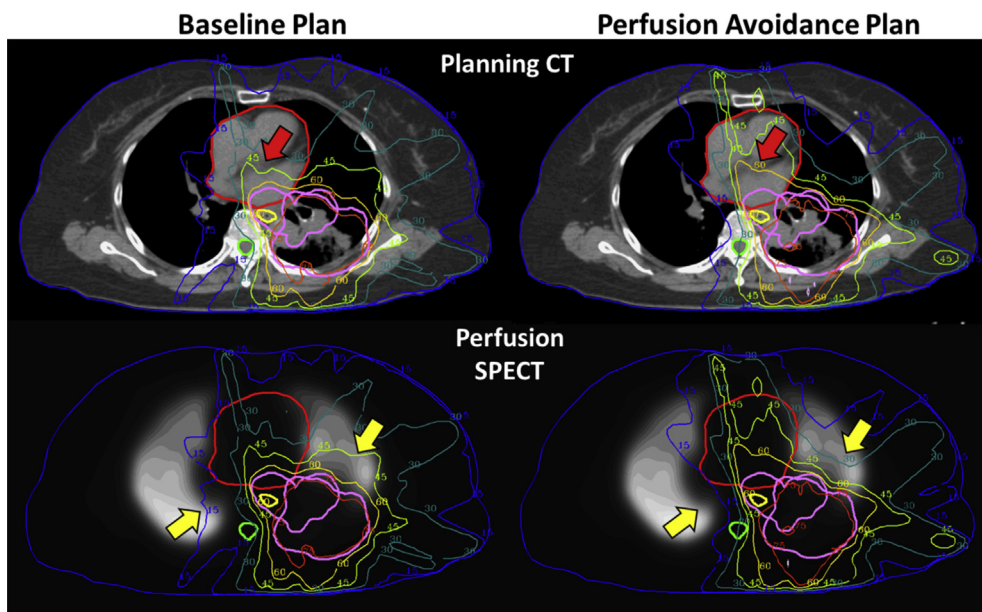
Dose distributions (in absolute physical dose) for the baseline and perfusion avoidance plans displayed on planning computed tomography and perfusion single photon emission computed tomography scans. Yellow arrows denote areas of dose redistribution away from the perfused lung, and the red arrow denotes an increase in heart dose as a result. The heart (thick red contour) mean and maximum dose limits are still met. Planning target volume (PTV) contours for both the nodal and primary PTV are shown in thick pink outlines (PTVs intersect on this slice).
